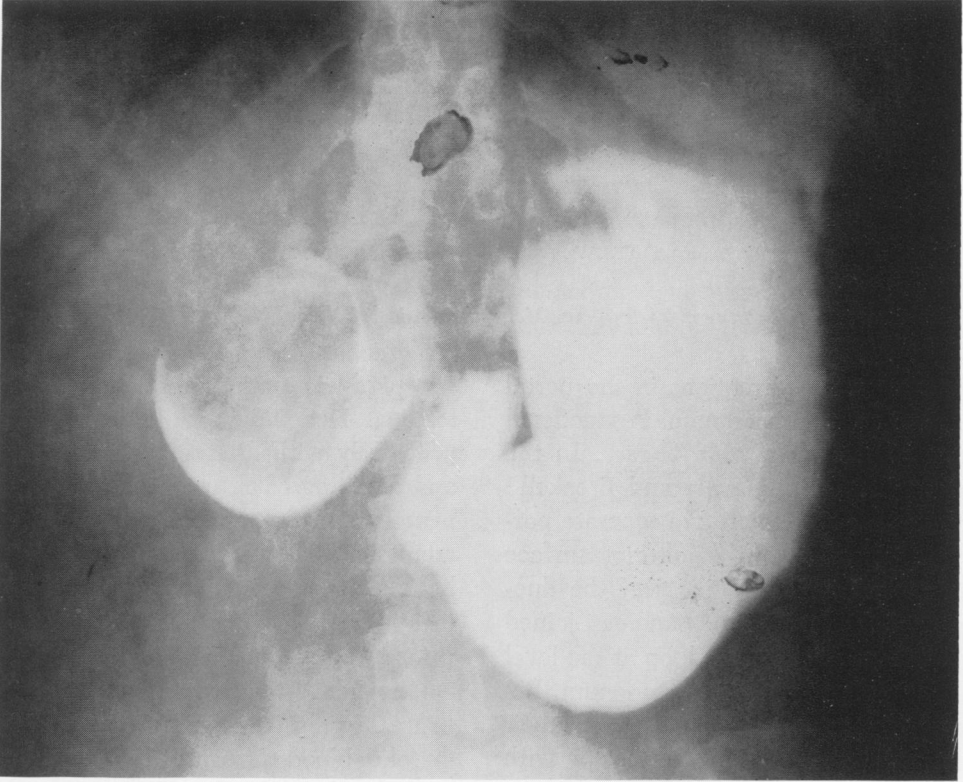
Preoperative upper gastro-intestinal x-ray showing apparent marked distention at pylorus.
